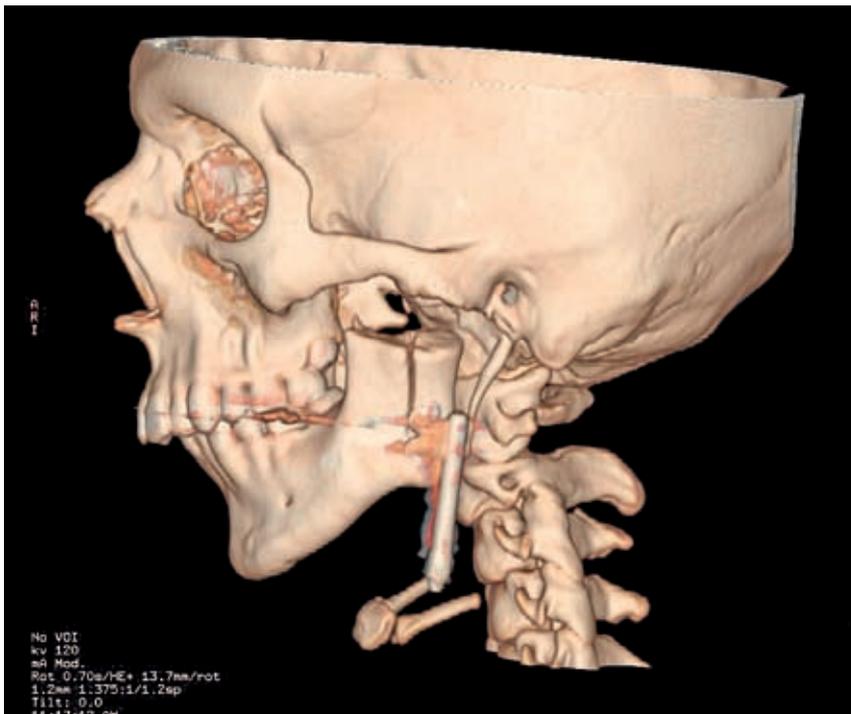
CT of the head of the patient with the distractor in the temporomandibular region
